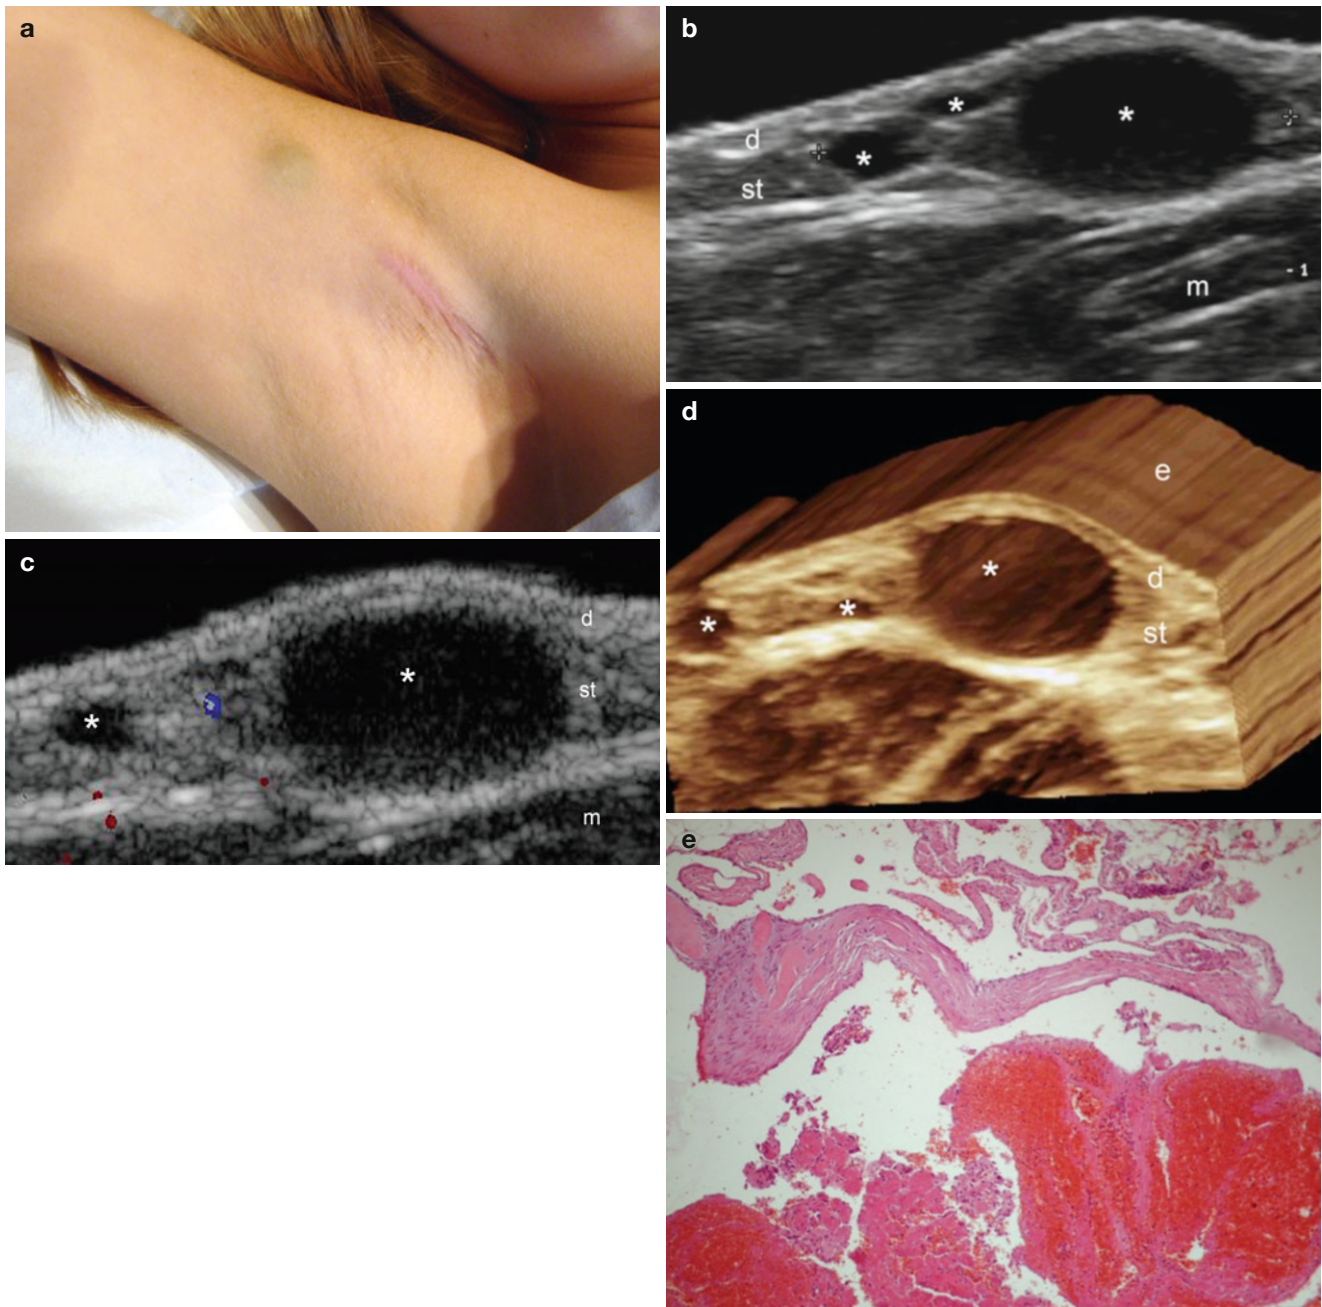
(a–e) Lymphatic vascular malformation. (a) Clinical image of a lesion in the right arm. The scar in the axilla corresponds to a previous surgical removal of the malformation (without pre-surgical ultrasound). (b) Ultrasound image (gray scale, transverse view at the right arm) shows multiple round and oval-shaped anechoic structures (*) of variable sizes in the subcutaneous tissue. (c) Color Doppler ultrasound
